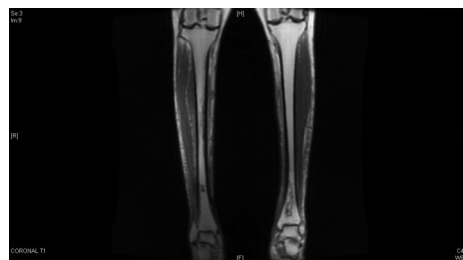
Coronal T1 MRI of lower extremities shows a curvilinear margin of low signal in the left distal tibia, consistent with bone infarction.
